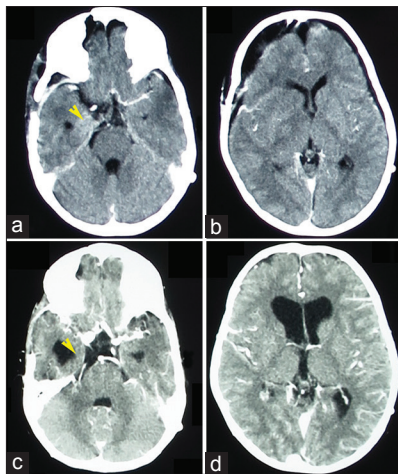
(a and b) Postoperative computed tomography (CT) scan showed a reduction of the tumor mass especially at the suprasellar region. (c and d) 1-year postradiotherapy CT scan, the enhancement of tumor remnant as shown on (a) (yellow arrowhead) was significantly reduced after radiotherapy (c), yellow arrow head]. Ventricle system was enlarged, but the shunt pump was still effective, and the patient did not complain any intracranial hypertension sign
